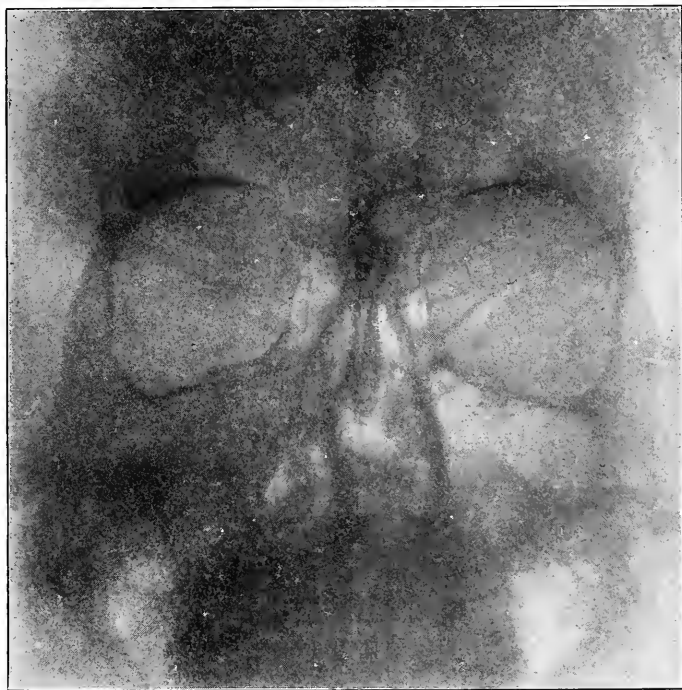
X-RAY SHOWING DISEASE OF ANTRUM ON RIGHT SIDE WITH PUS.
